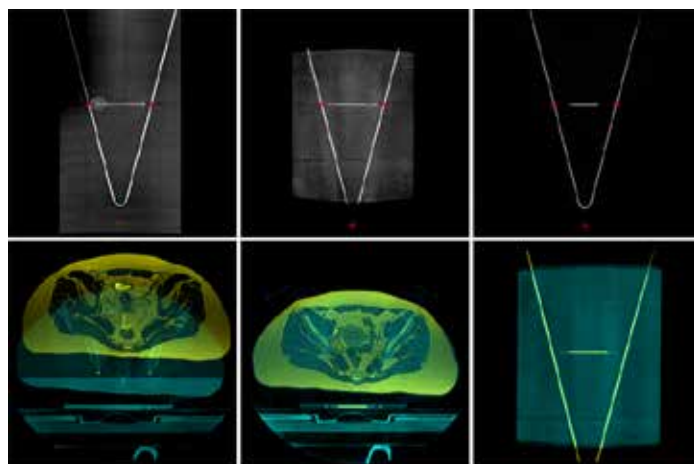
Top row: Contrast agent filled hoses with detected features (red crosses) in CT (left), CBCT (middle) and T2 weighted MRI (right). Bottom row: Unregistered fusion of fraction CBCT (cyan) and MRI (yellow) (left); Registration result in transversal view (middle) and in coronal view (right). hoses in CBCT and MRI are accurately aligned in both orientations.
